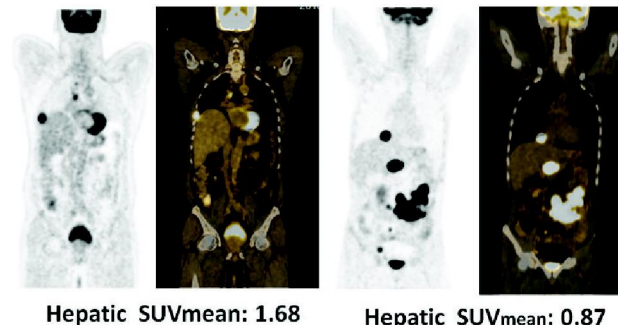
FDG PET and PET/CT images with Hepatic SUV_{mean} within and below bench mark of 1.3 -3%.
